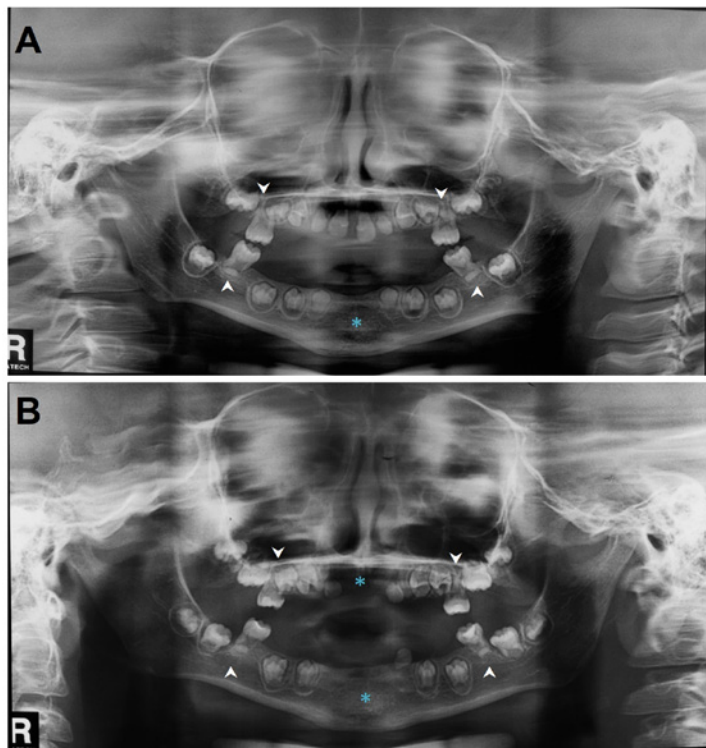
Panoramic X-rays. 'A': At age five. 'B': At age six. Absence of deciduous and permanent teeth in the region of the upper and lower incisors (*) and alteration in root formation and tooth size, as well as taurodontism (arrowhead).
